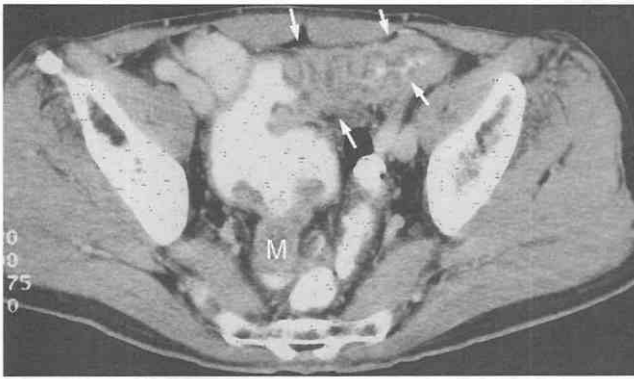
Rectal cancer in the proximal colon in a patient with colitis. CT scan shows a mass (M) in the sigmoid colon along with proximal colonic dilatation. Bowel wall thickening with a target appearance (arrows), also shown in the proximal sigmoid colon, was confirmed as ischemic colitis on pathologic examination. Note the skipped area between tumoral and ischemic segments. (From Rha SE, Ha HK, Lee SH, et al: CT and MR imaging findings of bowel ischemia according to the various primary causes. *Radiographics* 20:29-42, 2000.)
